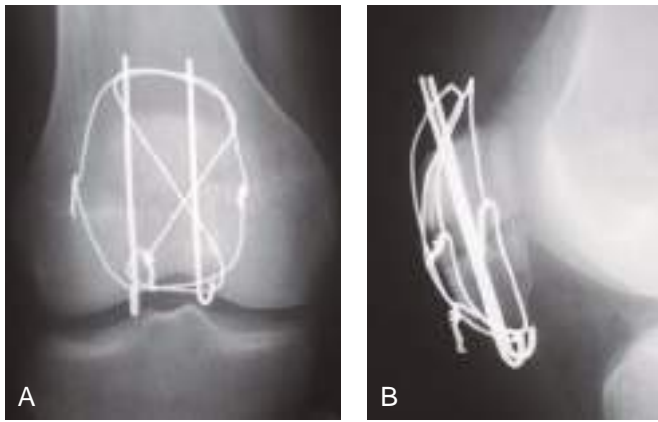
Internal fixation with cerclage wires and pins. (A) AP radiograph and (B) lateral radiograph of compression wiring fixation of patellar fracture. Same patient as in Fig. 1.2.
